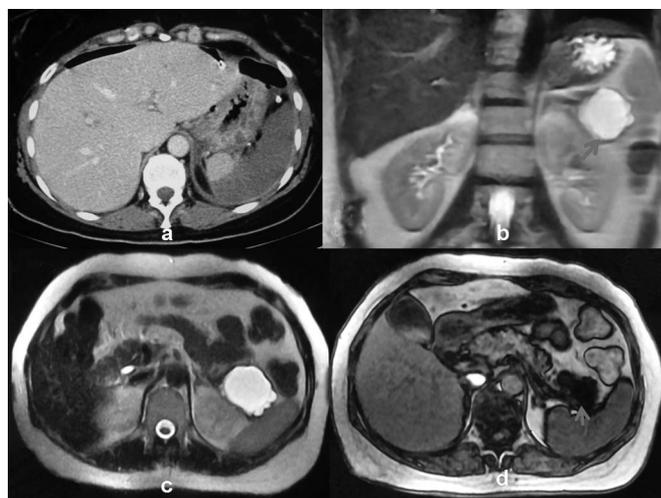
(a) CT image showing a cystic lesion in the tail of pancreas. (b-d) MRI images displaying a unilocular, homogeneous, low-attenuated and well-demarcated cystic mass.
